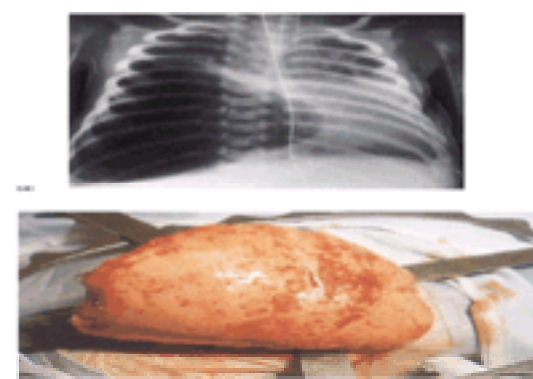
(a) Chest radiograph of an infant with congenital lobar emphysema involving the right lower lobe. Distension of this lobe had progressed over several days with worsening pulmonary function because of compression of the remaining normal lobes. (b) At surgery the emphysematous lobe protruded through the thoracotomy incision immediately improving arterial gases.
